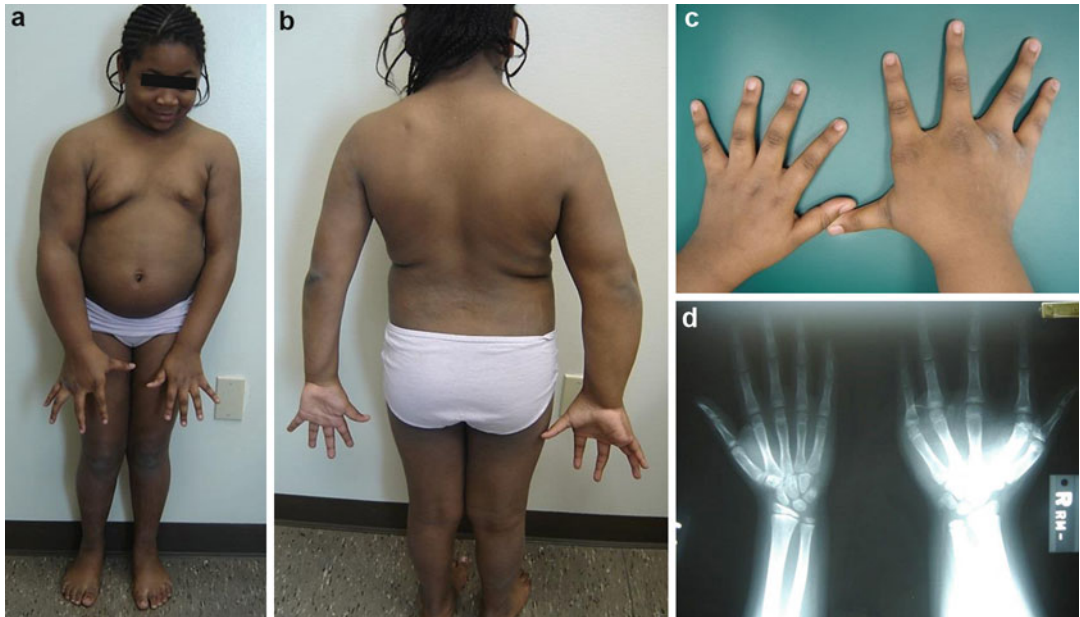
(a–d) A 7-year-old girl with hemihypertrophy of the *right upper* extremity. The radiograph of the forearms and hands showed osseous and soft tissue hypertrophy. She is otherwise normal
